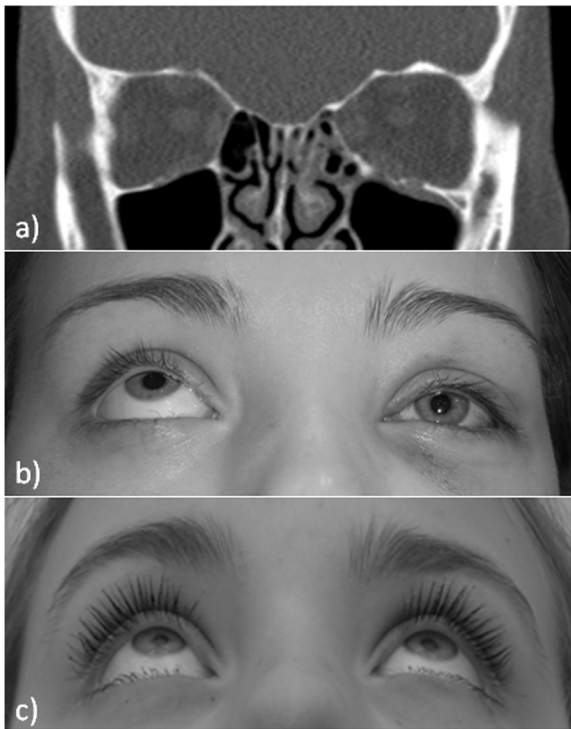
CT scan (a) of a patient with left orbital wall fracture, with limitation to elevate the left eye 1 day after the injury (b), and normal eye movement at 1 year postoperative (c). This patient was considered to have entrapment of the left rectus inferior muscle.
